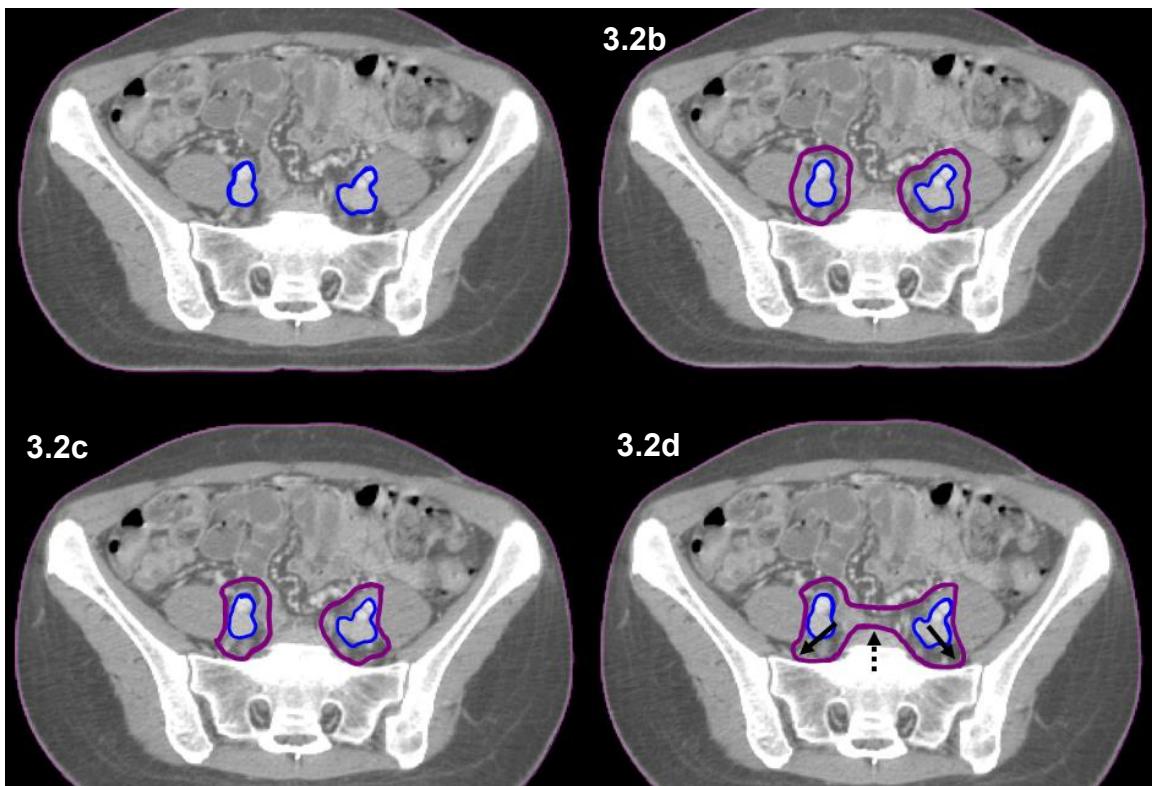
(a) Axial CT image at the level of iliac bifurcation with vessels (blue). (b) 7mm margin added (purple). (c) edited to exclude muscle and bone (d) extended posterolaterally to include area between psoas muscle and vertebral body (solid arrow) and addition of a presacral strip (dashed arrow d)
